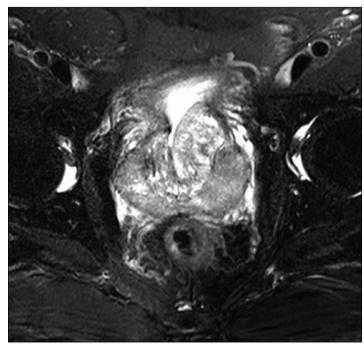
Contrast-enhanced magnetic resonance imaging showing clear enhancement in the early phase of the lesion.
